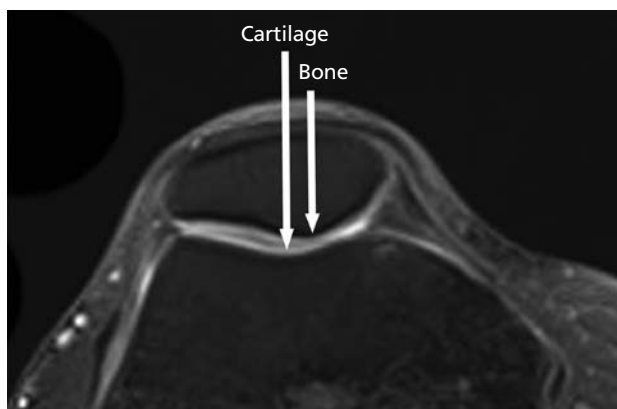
Non-matching cartilaginous and osseous geometry of the patella on axial MRI.
